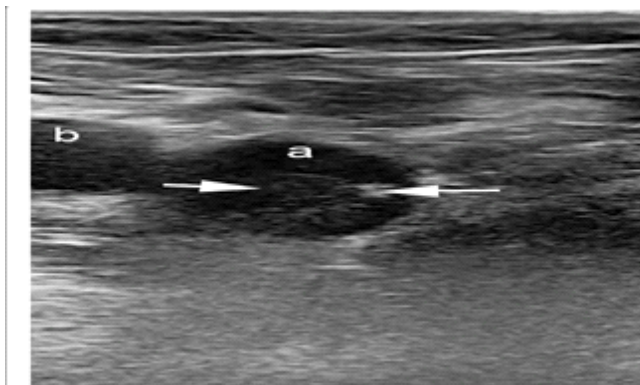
A person with compression ultrasound confirmed DVT by color Doppler ultrasound [9]
